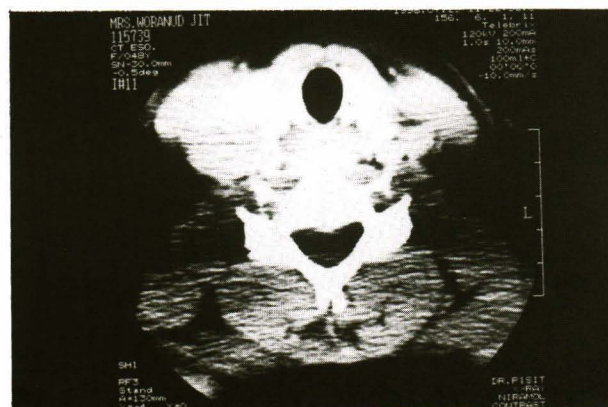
CT scan showed soft tissue mass at postcricoid and cervical esophagus.
